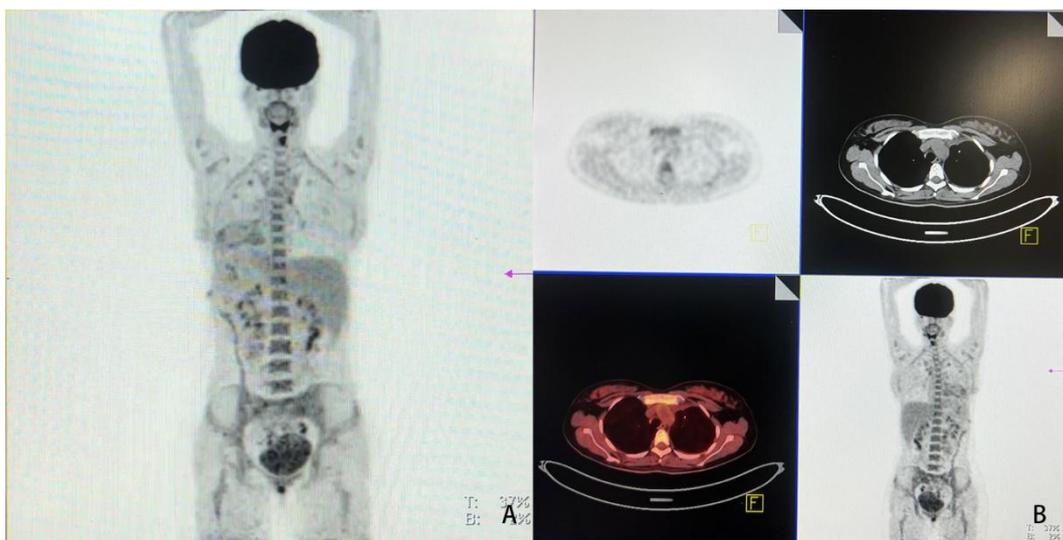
Lymph nodes before the carina were developed, the possibility of inflammatory lesions was considered high (A), and a small amount of effusion in the left chest, no FDG metabolic abnormalities in the left residual lung, and no signs of local tumor infiltration (B).
